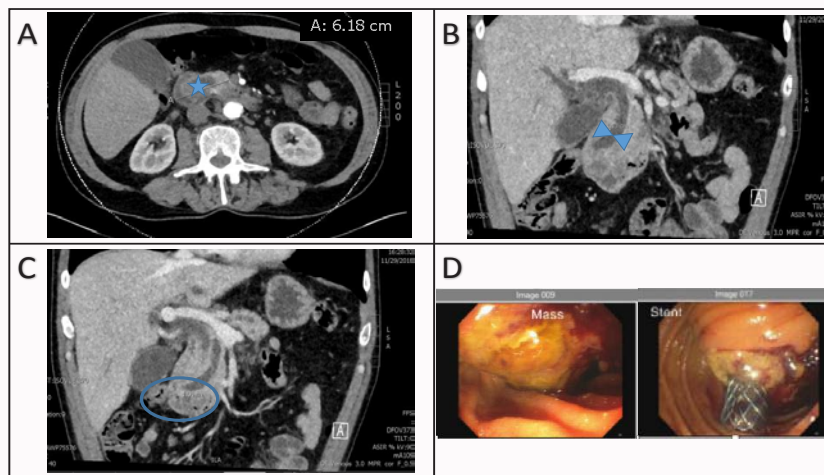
CT Initial diagnostic imaging and tumor visualization on endoscopic ultrasound – pancreatic head mass causing common bile duct/pancreatic duct dilation. A) CT Transverse plane showing widest tumor dimension along the pancreatic head (blue star). B) CT Coronal view showing pancreatic head mass extending into duodenum (blue circle). C) CT Coronal view showing common bile duct dilatation to 1.13 cm (blue arrowheads). D) Gross anatomic view from EUS showing pancreatic head mass protruding into duodenum before and after biliary stenting.
